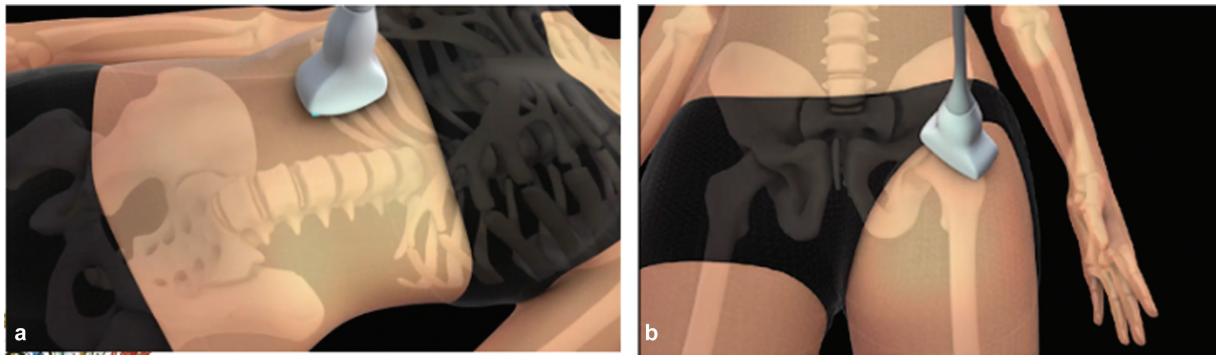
(a) Ultrasonography (US) acquisition on an axial anatomical site of the lumbar vertebrae. (b) US acquisition on an axial anatomical site of the femoral neck.
